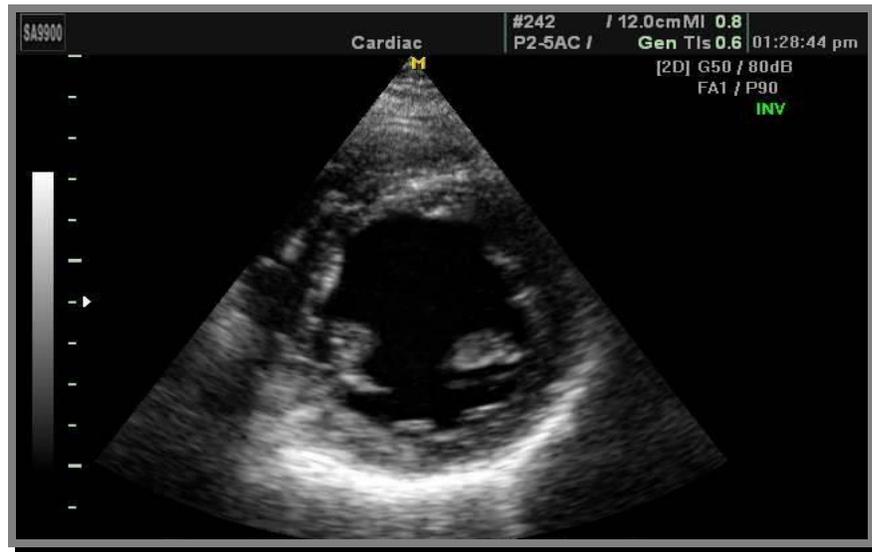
Parasternal short –Axis Views.*
